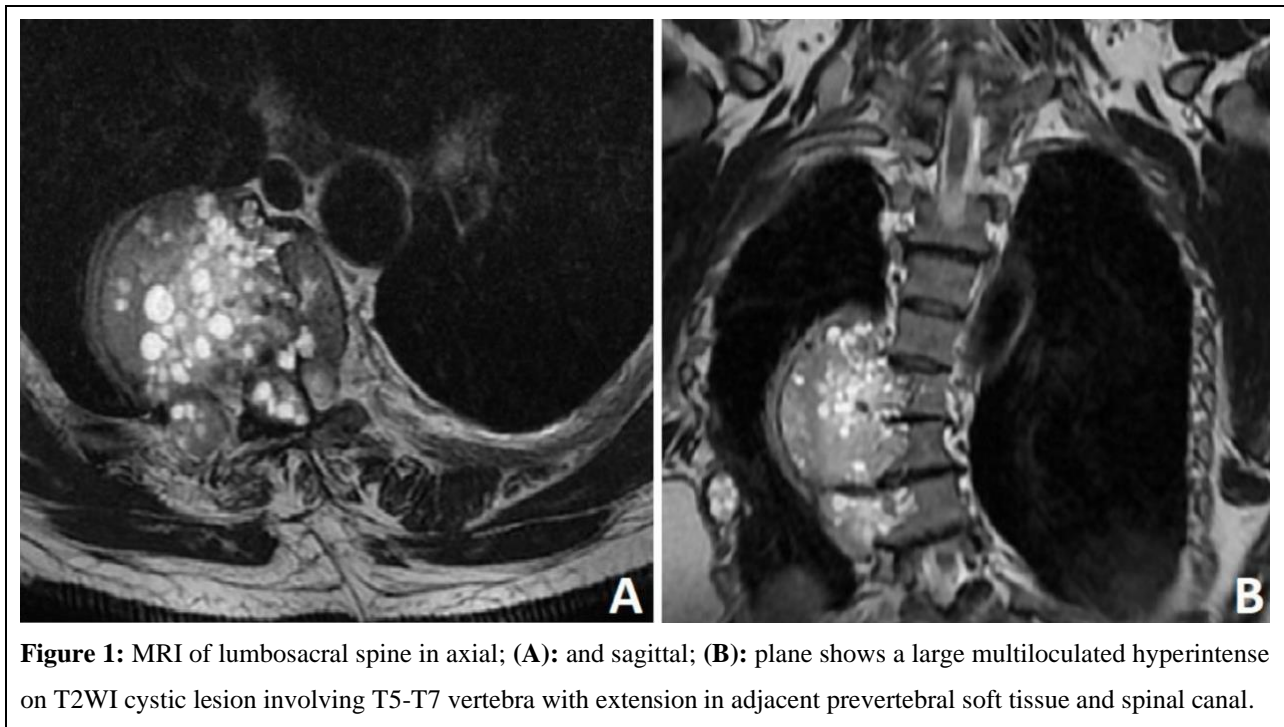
MRI of lumbosacral spine in axial; (A): and sagittal; (B): plane shows a large multiloculated hyperintense on T2WI cystic lesion involving T5-T7 vertebra with extension in adjacent prevertebral soft tissue and spinal canal.
